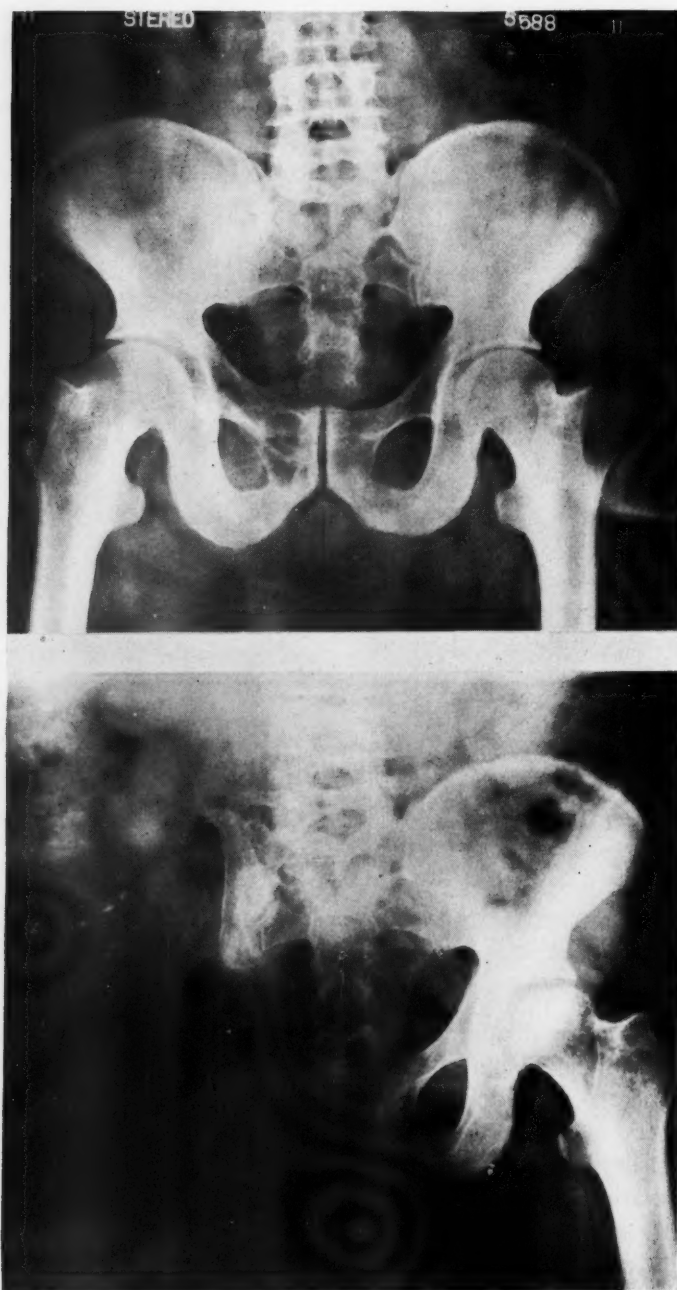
Roentgenogram of pelvis, showing chondrosarcoma of right pubis and ischium in Case 3. A favorable tumor for treatment by sacro-iliac disarticulation.
